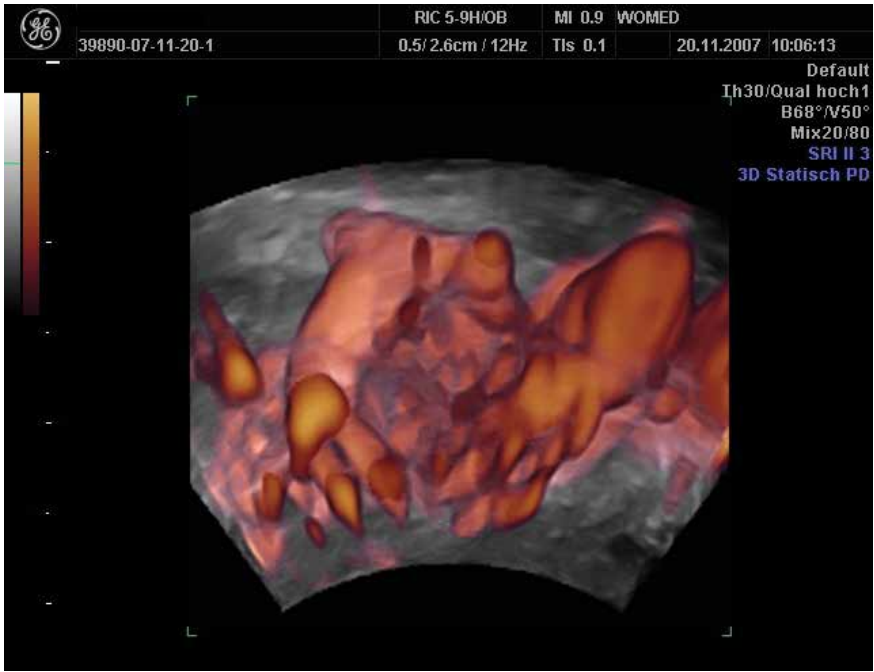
Case 2. Chronic recurrent thyroiditis in 3-D power Doppler modulus using a vaginal transducer. Note the increased vascularity as compared to Figure. 3
